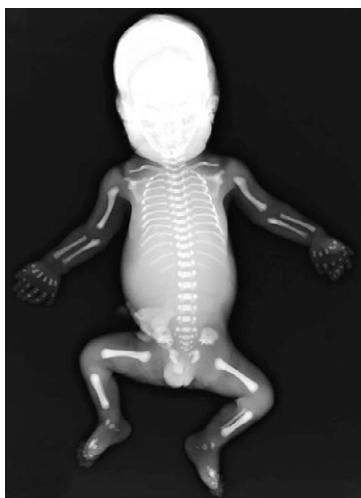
Whole body X-ray of proband 1 at 28 gestational weeks.
